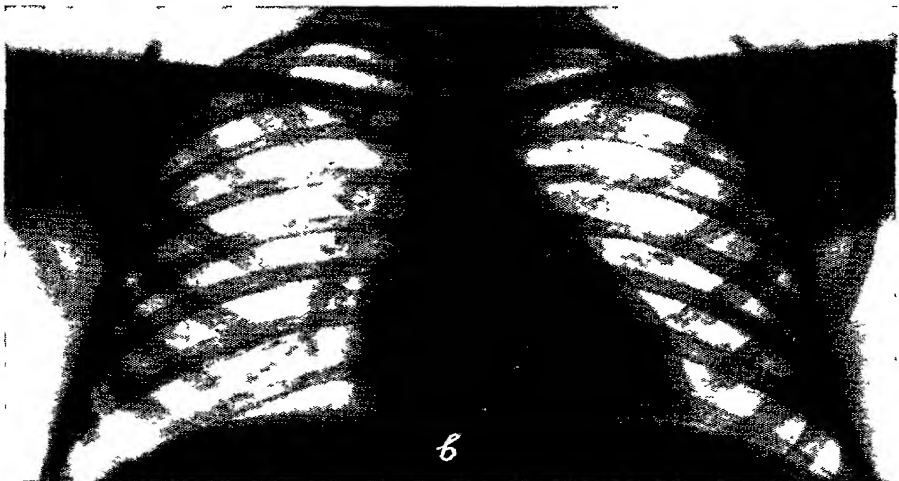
X-rays of the same patient after treatment
